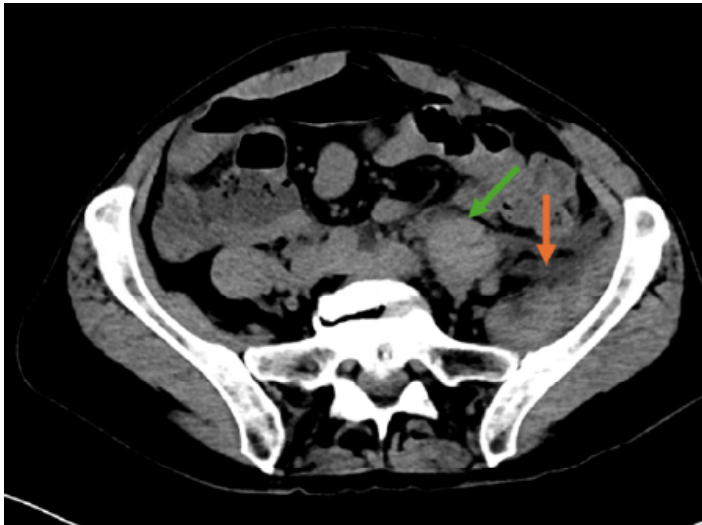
Lower sections of computed tomography abdomen and pelvis demonstrates heterogenous hyper-attenuation of the left psoas major muscle (green arrow) and iliacus muscle (orange arrow).
